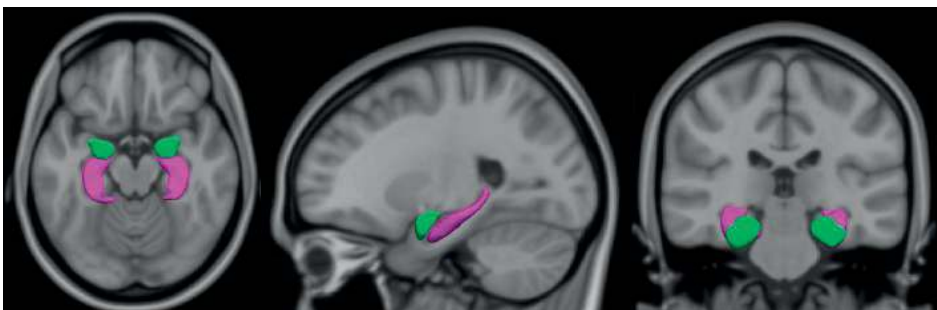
T1-weighted MRI scan (axial, sagittal and coronal view) showing the amygdala (in green) and hippocampus (in purple) segmentation.
